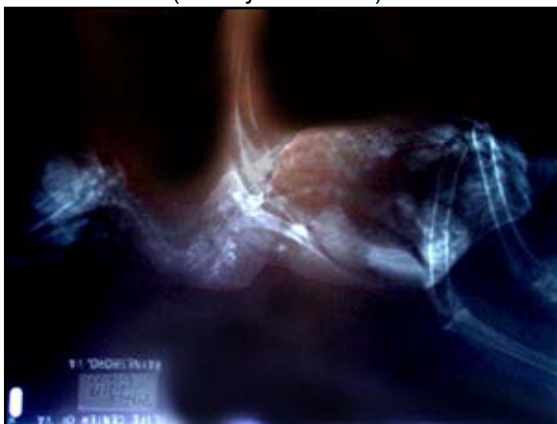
Radiographs of an immature red-tailed hawk (*Buteo jamaicensis*) with a prominent parabronchial pattern.
